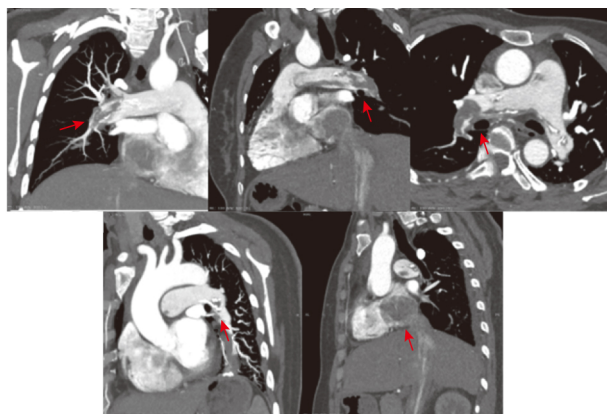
Computed tomographic pulmonary angiogram revealed multiple filling defects (red arrows) in the segmental and subsegmental branches of both pulmonary arteries.
